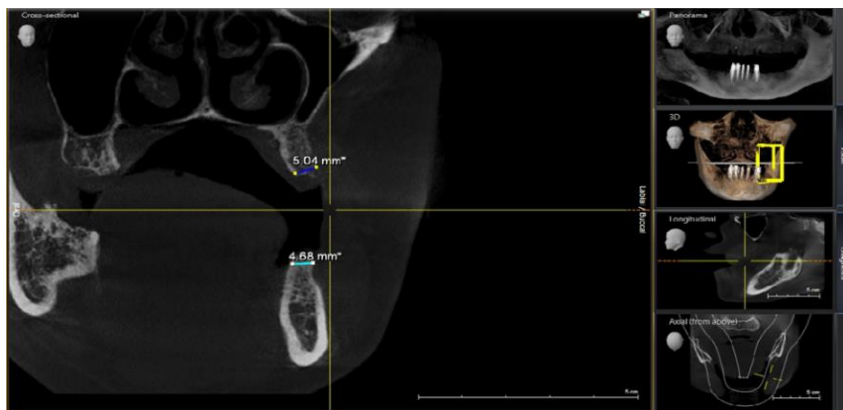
preoperative Cone Beam CT Scan showing the bone thickness on 26 and 36.
